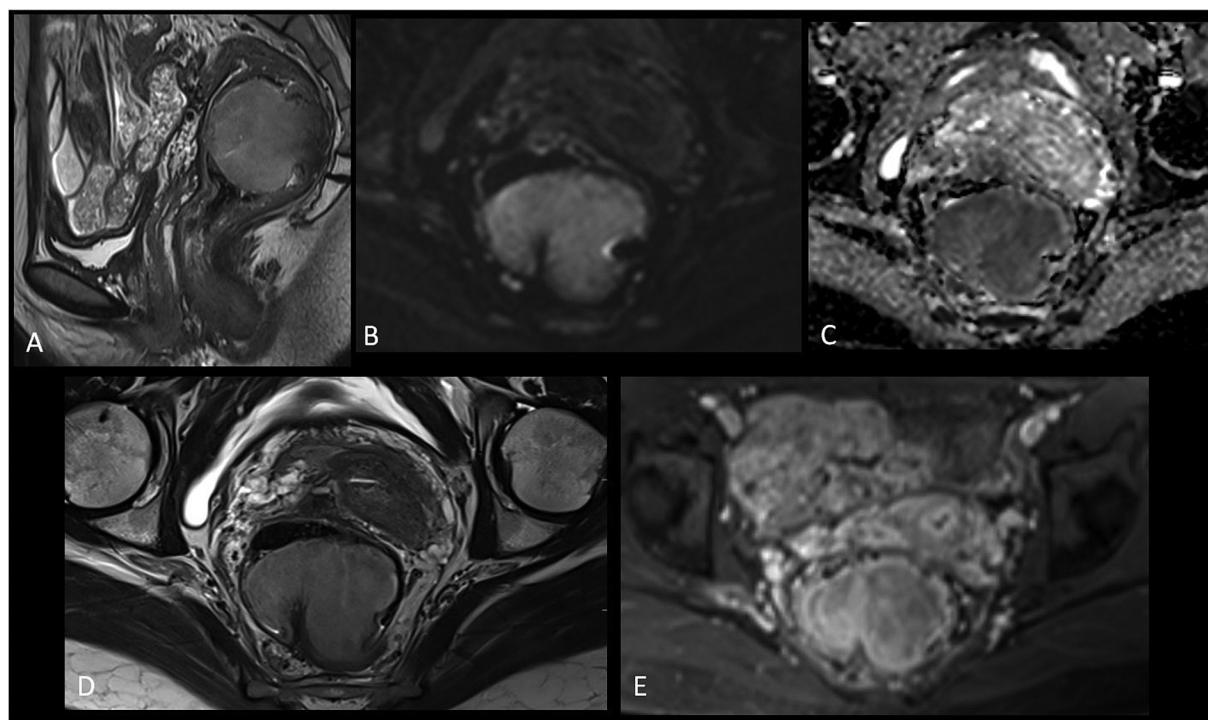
CEMRI PELVIS: T2 sagittal (A), DWI and ADC (B and C), T2 axial (D), and post-contrast T1 axial (E). Polypoidal pedunculated hyperintense altered signal intensity mass in upper-mid rectum (A) measuring 4.7 AP \times 5.9 TR \times 4.9 CC cm with a peduncle hypointense stalk length of 2.8 cm approx. in CC extent., showing diffusion restriction with low ADC (B and C) and heterogeneous contrast enhancement (E). ADC, apparent diffusion coefficient; DWI, diffusion-weighted imaging.
